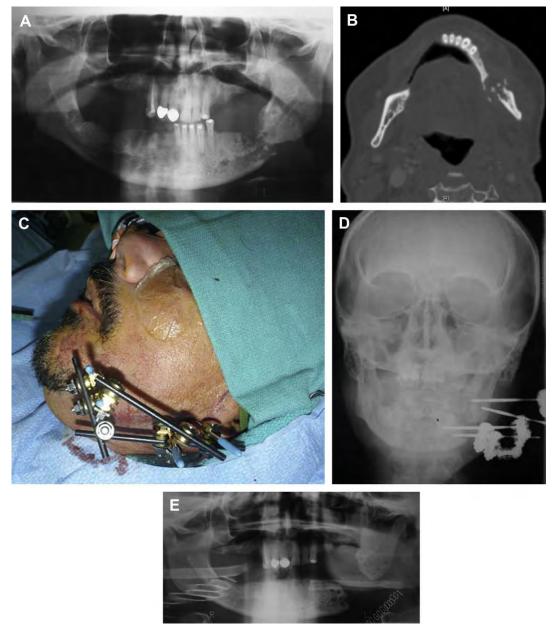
(A) A 58-year-old male patient with osteoradionecrosis and infected pathologic fracture of the left mandibular body, as demonstrated in the panoramic film. (B) Axial CT demonstrates the extent of the osteoradionecrosis. (C) External fixation device is in place until completion of hyperbaric oxygen therapy. (D) Postoperative Postero-anterior cephalogram shows pin placement. (E) Panoramic film depicts subsequent debridement of the fracture and removal of the appliance.
